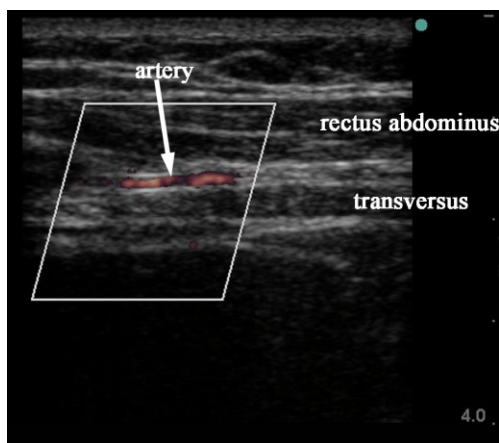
sonogram of the superior epigastric artery near the costal margin highlighted by power Doppler
